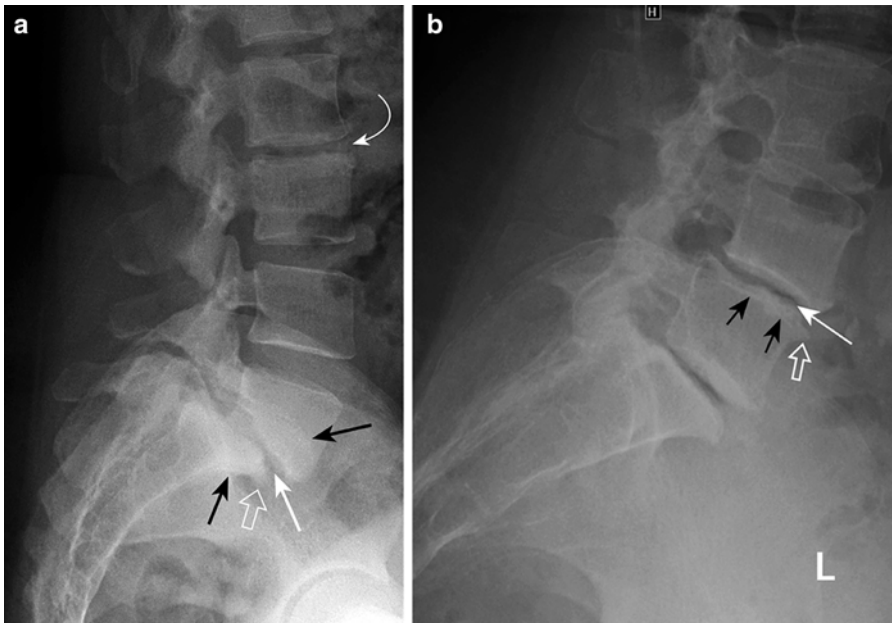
Spondylolisthesis with degenerative disc disease in two patients. (a) Lateral radiograph of the lower lumbosacral spine demonstrates anterolisthesis at L5–S1. The hallmarks of degenerative disc disease are seen at this level including disc space narrowing (*straight white arrow*), osteophyte formation (*open white arrow*), and endplate sclerosis (*black arrows*). Similar but less
